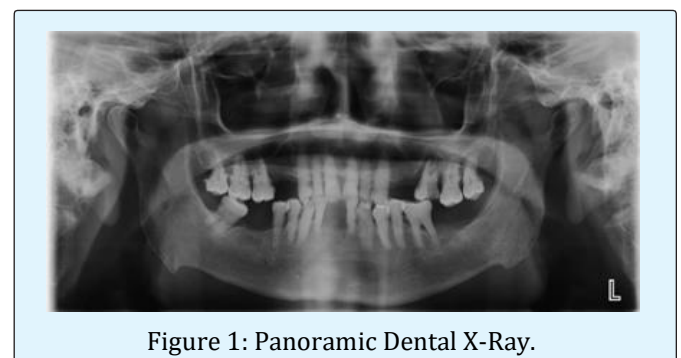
Panoramic Dental X-Ray.
